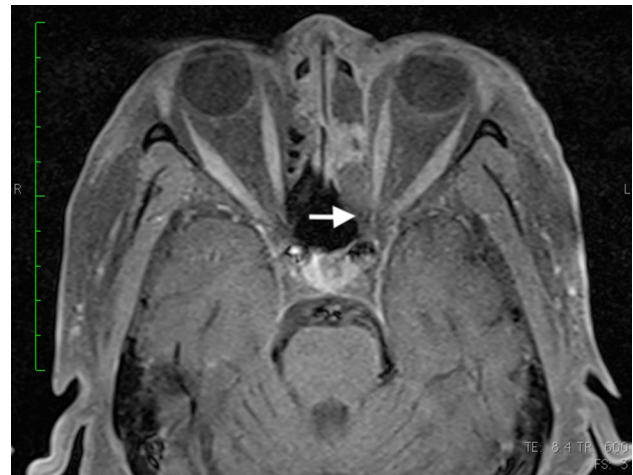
Post-contrast fat suppressed T1 axial MRI showing hypointense shadow near left orbital apex (white arrow)
